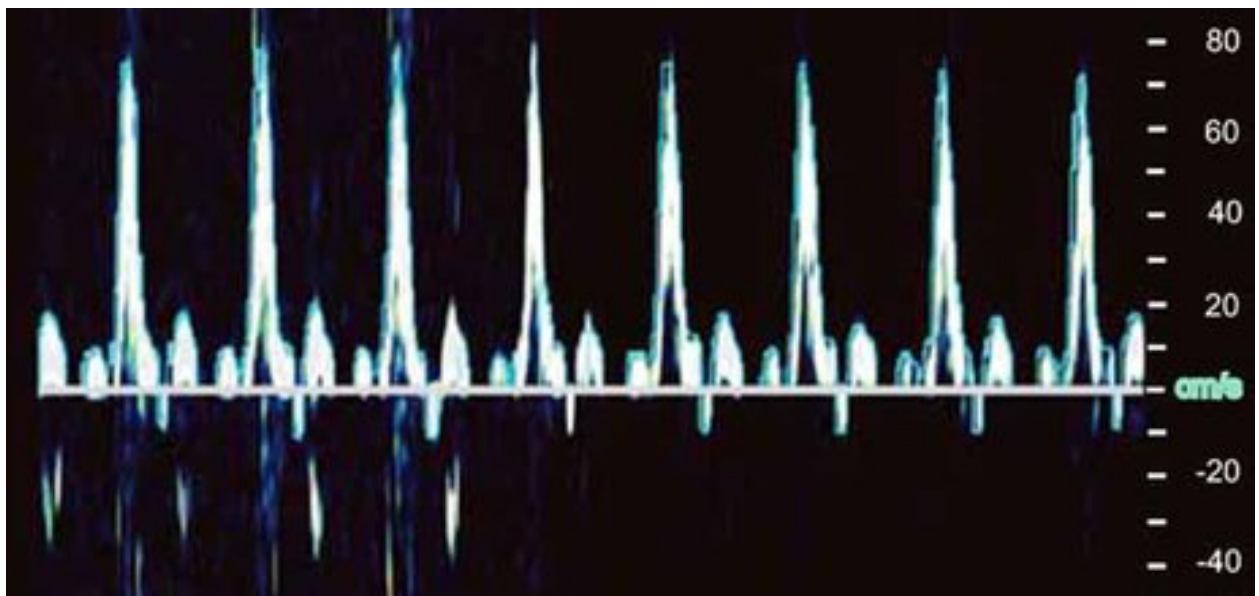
Doppler US image of a healthy brachial artery showing typical tri-phasic arterial flow
